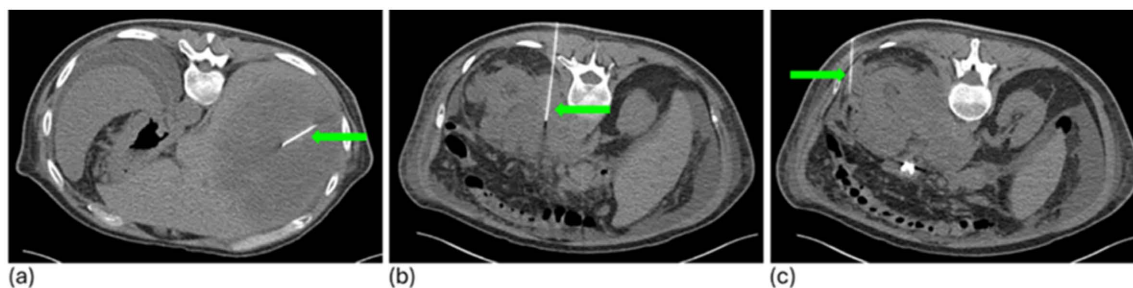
The first CT-guided percutaneous CIPI™ procedure shows intratumoral drug delivery into the (a) right liver mass, (b) left adrenal gland mass, and (c) left pararenal metastatic lesions, using a 22-gauge spinal needle (shown with a green arrow).
